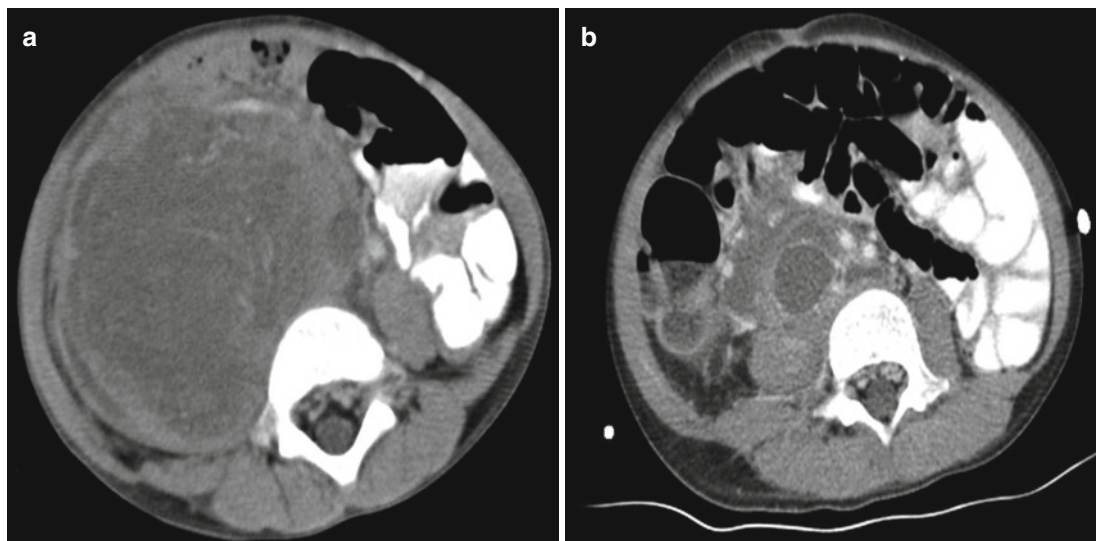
(a) A 3 year-old girl presented with an enlarging, painless abdominal mass. CT abdomen and pelvis confirmed an 11.5×9.5×9.5 cm right retroperitoneal mass encasing the abdominal aorta. Open biopsy showed embryonal RMS, and she was started on
